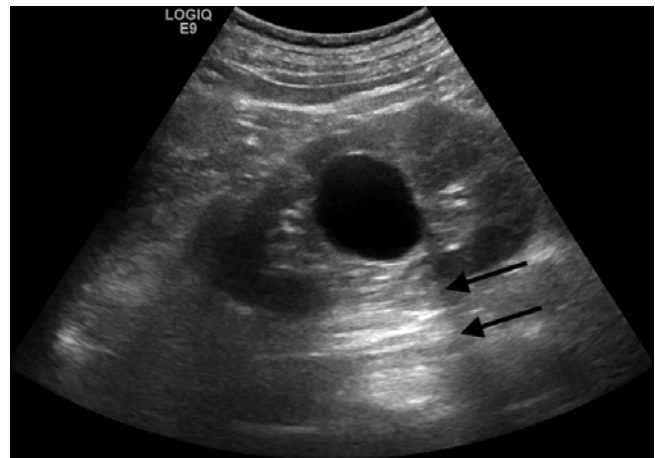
Renal cyst. Sagittal sonographic image of the left kidney demonstrates a well-circumscribed, anechoic, thin-walled lesion with posterior acoustic enhancement (*black arrows*), a finding which is often used to definitively characterize a lesion as cystic. At the lateral edges of the enhanced echoes, there is a faint shadow representing *edge (refraction artifact)* which results from bending of the sound wave from its expected path
